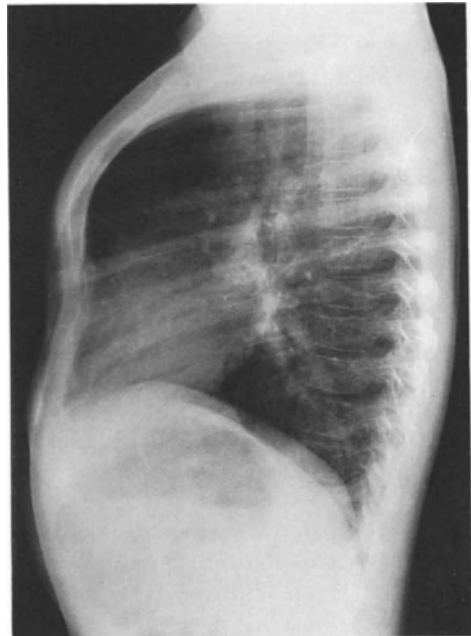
High-protusion deformity: lateral X-ray (Currarino-Silverman syndrome)
